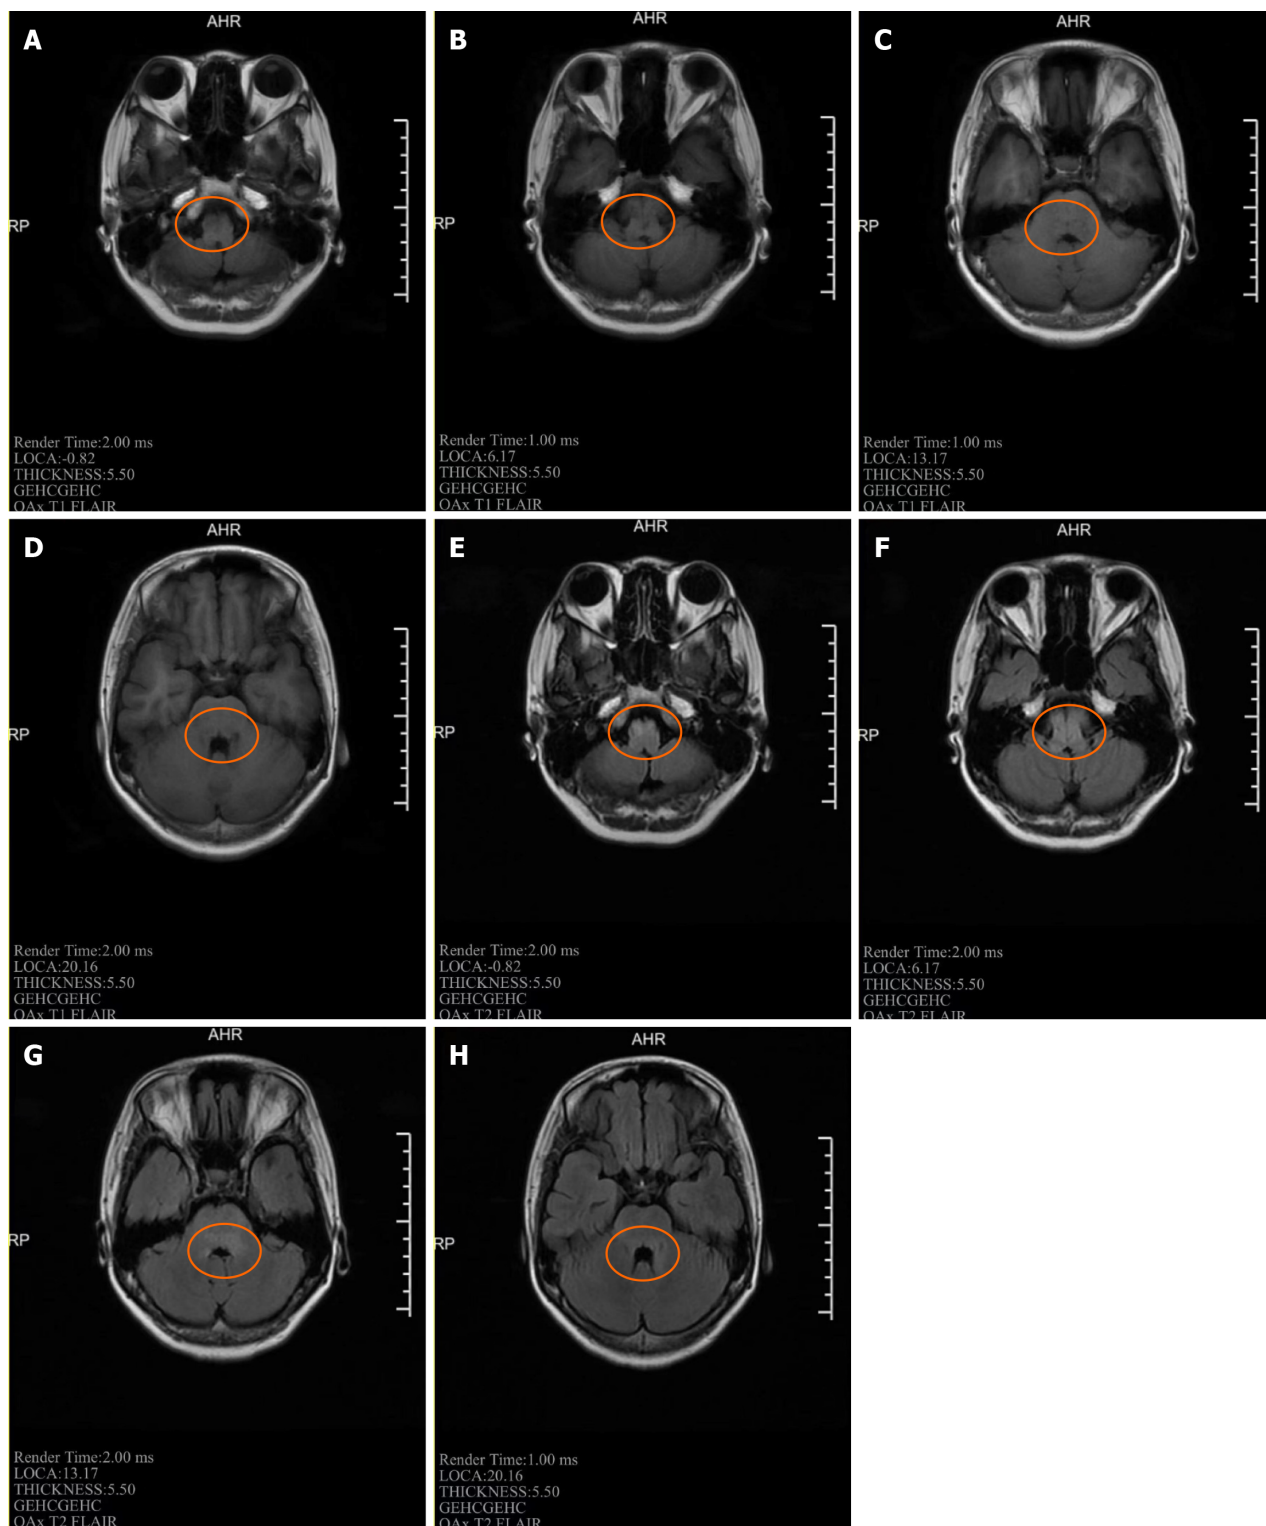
Patient's first brain magnetic resonance imaging. A-D: Four slices of diffusion-weighted imaging showing slightly high and equal signals in the medulla oblongata; E-H: Four slices of apparent diffusion coefficient showing normal value in the medulla oblongata.
